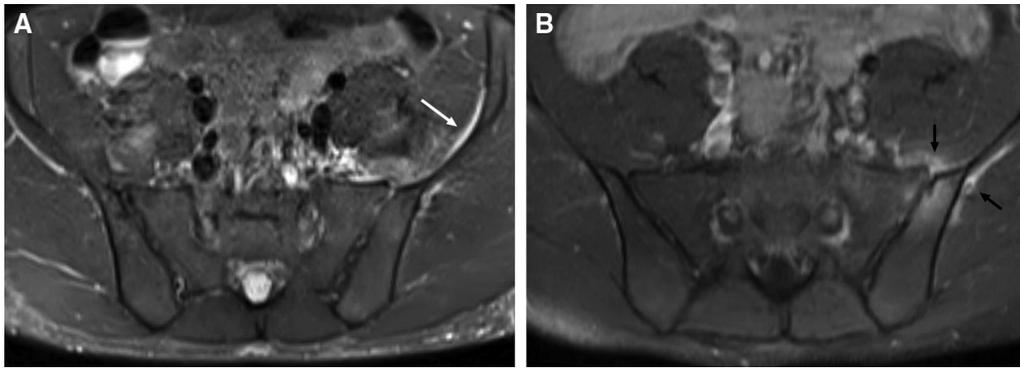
Unilateral infective sacroiliitis in a 25-year-old man presenting with pyrexia and severe left sacroiliac joint pain. He gave a history of repeated intramuscular injections for chronic back pain. (A) Axial short tau inversion recovery image shows subtle areas of bone marrow oedema on both sides of the left sacroiliac joint with a trace amount of fluid along the left iliacus and gluteal muscles (white arrow). (B) Axial fat-saturated T1-weighted postcontrast image demonstrates enhancement of the left sacroiliac joint and muscles (black arrows) raising concern for infective sacroiliitis. *Bacteroides fragilis* was cultured on aspiration.
